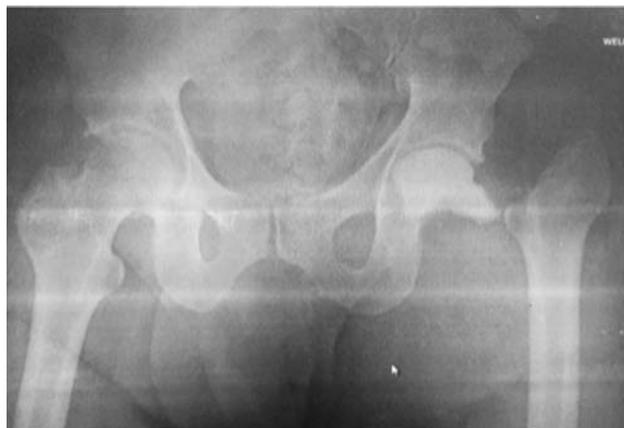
Panoramic anteroposterior radiograph of the pelvis after the resection of the femoral head and placement of a non-articulated spacer.
